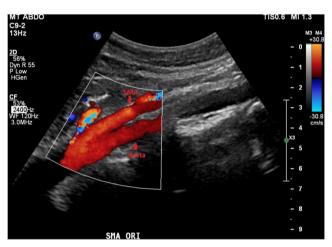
Case 1 Color Doppler demonstrated no focal stenosis at SMA origin.
